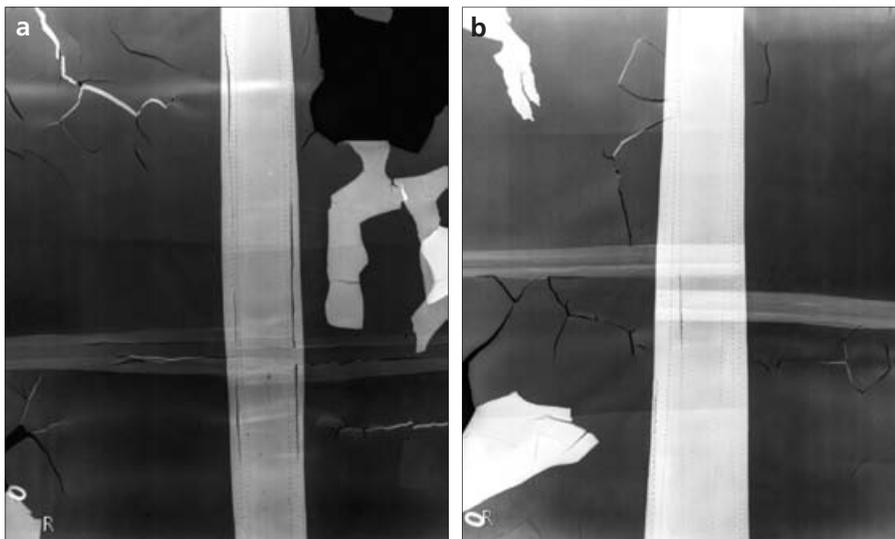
a, b. The rips, cracks, and defects on the aprons are seen on the X-ray films, indicating that the aprons should be discarded.
